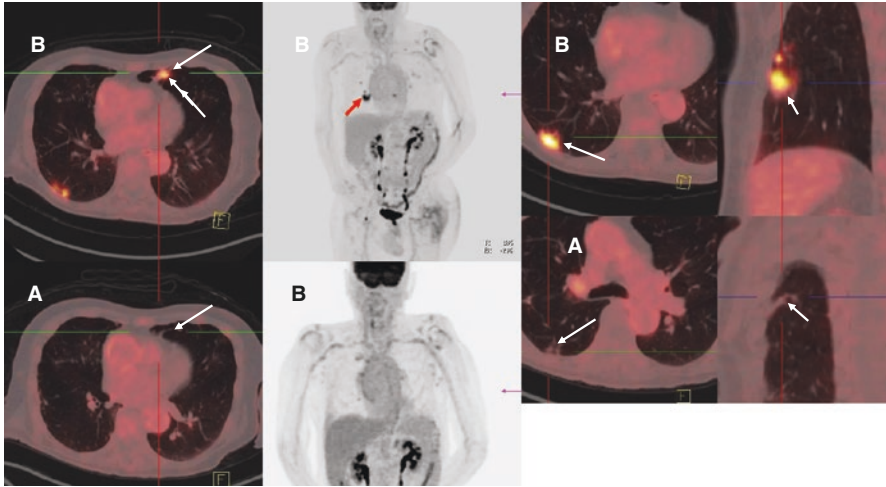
FDG PET Scans A (2018) and B (2019) in a patient with known culture positive non-tubercular mycobacterial (NTM) multi-drug resistant (MDR) infection. Scans (A) axial and coronal and FDG MIP's after treatment in 2018, demonstrate relative tracer quiescence i.e. lack of FDG activity within the peripheral parenchymal changes. Scans (B) in 2019 performed when symptoms recurred, show FDG positive focal nodular consolidation (white arrows) in keeping with recurrence of an active infection
